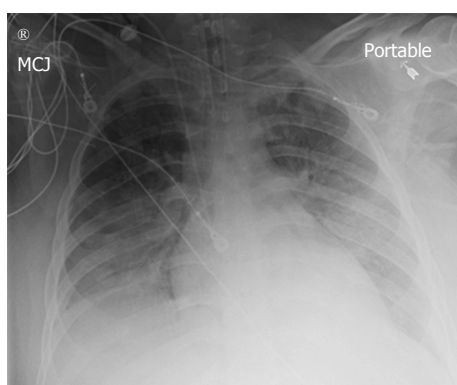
Patient's anterior-posterior chest X-ray film on extracorporeal membrane oxygenation day 2.
